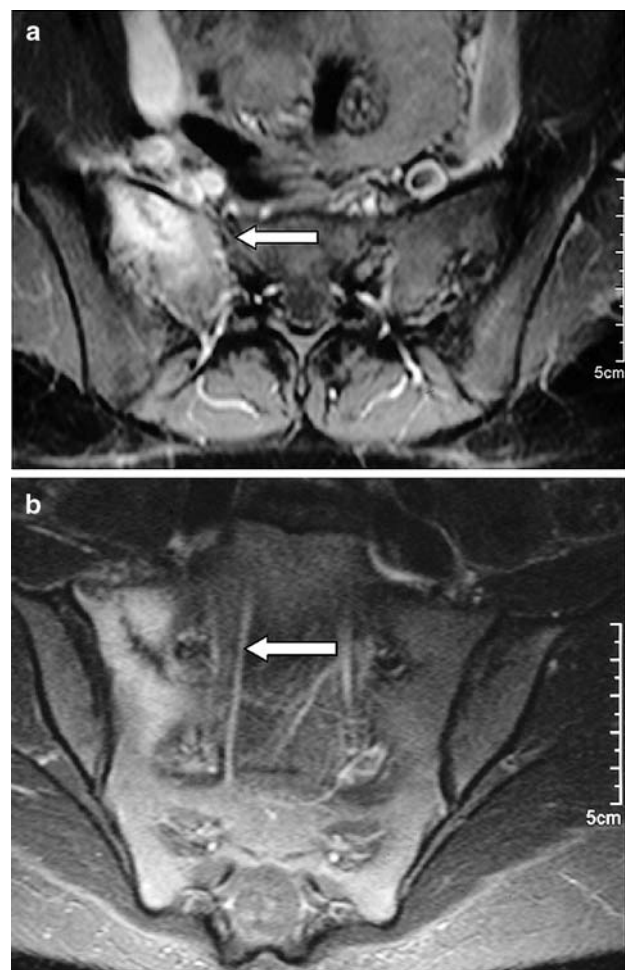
Magnetic resonance imaging of the sacrum demonstrating a bone marrow odema at the right massa lateralis and a tiny fracture line as a sacrum stress fracture of the fatigue-type
